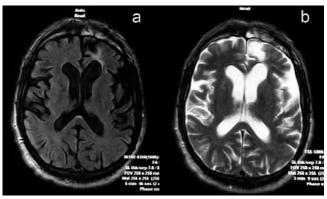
Postoperative T1 (a) and T2 (b) weighted MRI.
